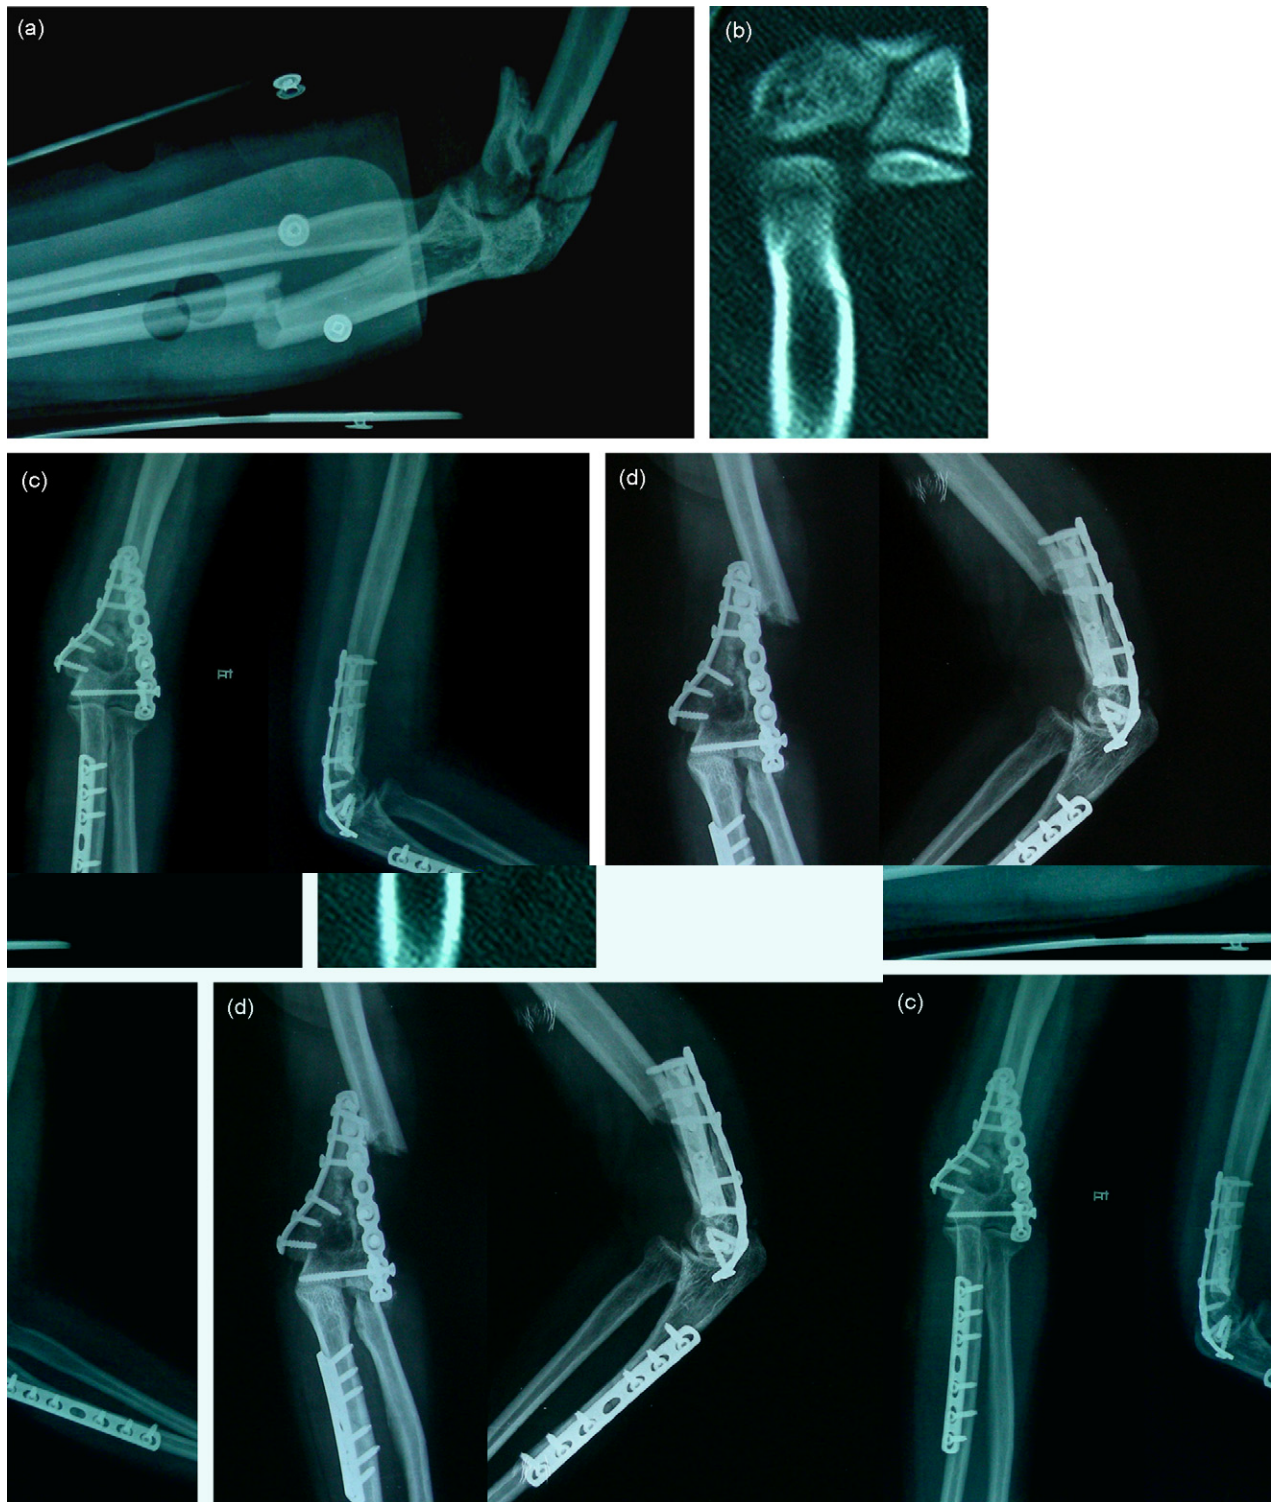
Lateral radiographs show an intra-articular fracture of the distal humerus (13C2 OTA) associated with a Monteggia fracture in the ipsilateral upper extremity. (A) Computed tomography demonstrates that the fracture involved the articular surface. (B) Open reduction with internal fixation was performed through medial and lateral elbow incisions and, 3 months after the operation, the fracture was clinically united; subluxation of the proximal radio-humeral joint was noted. (C) A humeral shaft fracture was found at the proximal end of the plate after the patient's second fall. (D) Open reduction with internal fixation was performed through the initial lateral incision and fixed with a 4.5-mm dynamic compression plate after removal of the posterolateral reconstruction plate. (E) All the fractures had united 12 months after the second operation. (F) The surgical incisions. (G) Final function of the affected elbow.
